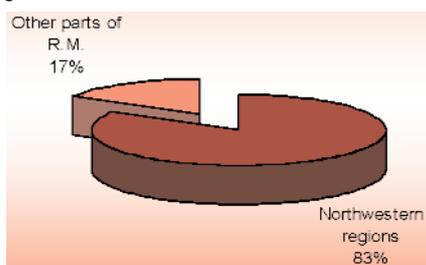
Out of the twelve documented cases with CT, 10 (83.3%) originated in crisis region (northwestern region)
